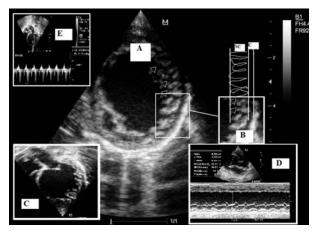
(A) Parasternal short axis view. The end-systolic still frame shows the two layered structure with thin epicardial layer and an extremely thickened endocardial layer with prominent trabeculations and deep recesses (arrows). (B) To quantify the thickness of the noncompacted layer at the site of maximum thickness, the end-systolic ratio of the noncompacted (NC) to compacted (C) layer is determined. (C) Apical four-chamber view still frame. (D) M-Mode study demonstrating LVEF- 30%. (E) mitral valve Doppler demonstrating regurgitation.
